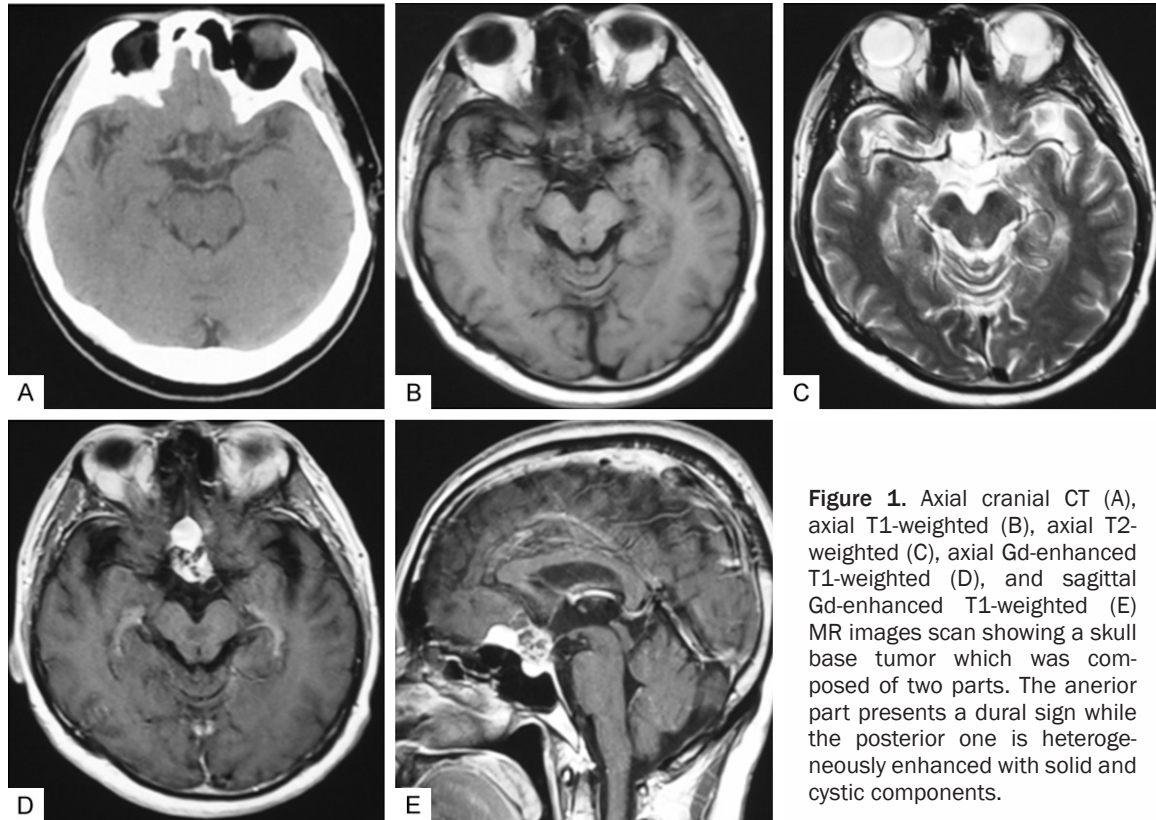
Axial cranial CT (A), axial T1-weighted (B), axial T2-weighted (C), axial Gd-enhanced T1-weighted (D), and sagittal Gd-enhanced T1-weighted (E) MR images scan showing a skull base tumor which was composed of two parts. The anterior part presents a dural sign while the posterior one is heterogeneously enhanced with solid and cystic components.
